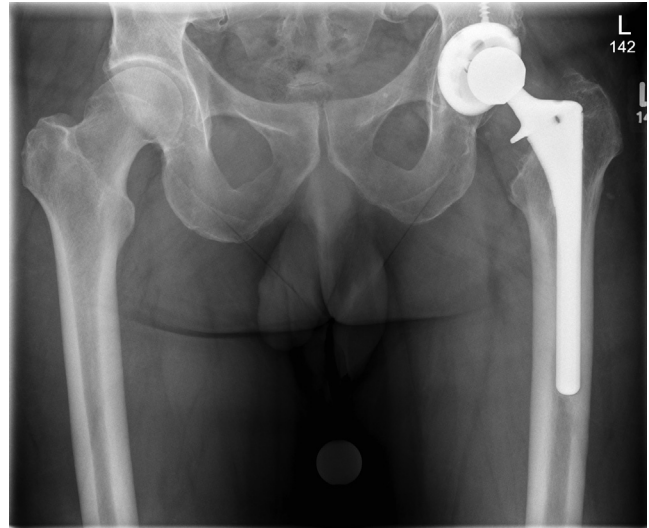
Anteroposterior pelvis radiograph of a 52-year-old man with a revision metal-on-polyethylene bearing surface THA and new diagnosis of MACC. The acetabulum and femoral stem appear to be well fixed. Osteolysis associated with his prior surgery has not increased over time.
